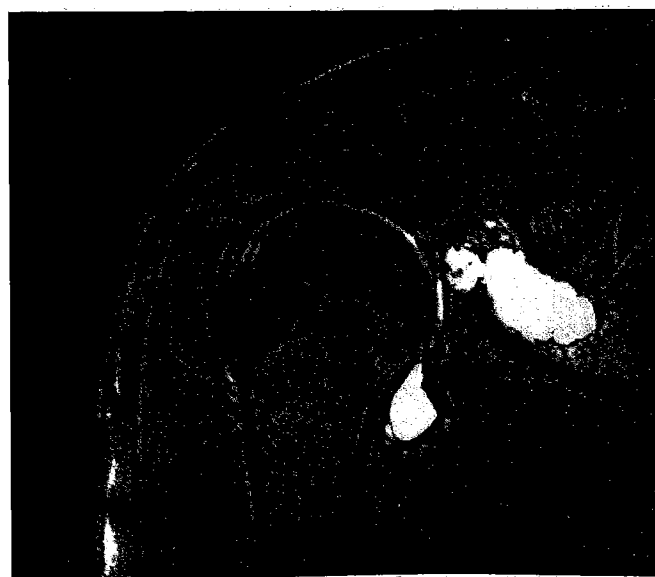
Magnetic resonance imaging of the right shoulder demonstrating a ganglion in the spinoglenoid notch compressing the infraspinatus branch of the suprascapular nerve.
